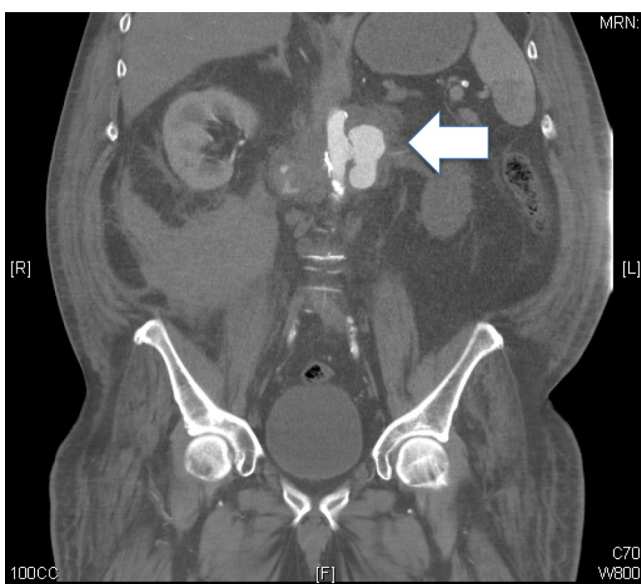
Contrast CT of the abdomen and pelvis showing aortic lumen, eccentric periaortic tissue, pseudoaneurysm/saccular aneurysm (arrow) that depends of left renal artery, and rupture of the right side of the infrarenal abdominal aorta with blood leakage and retroperitoneal hematoma.
